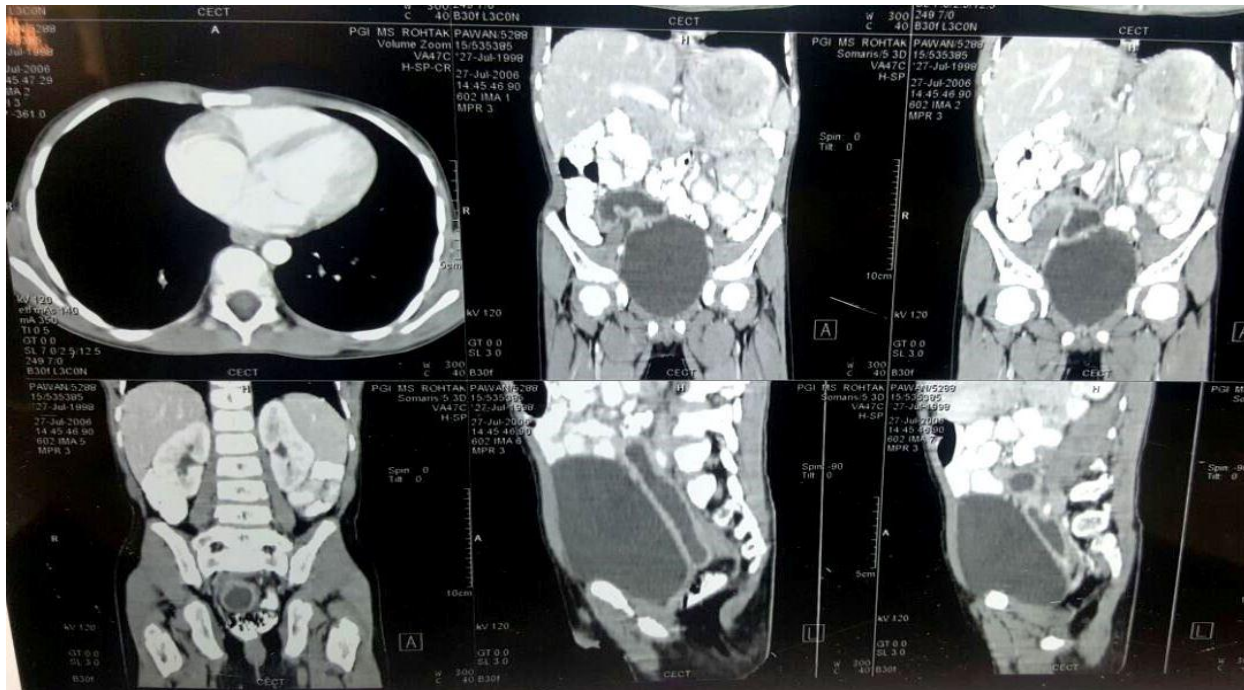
CT showing a well defined cystic lesion with thick enhancing wall in recto sigmoid region.
